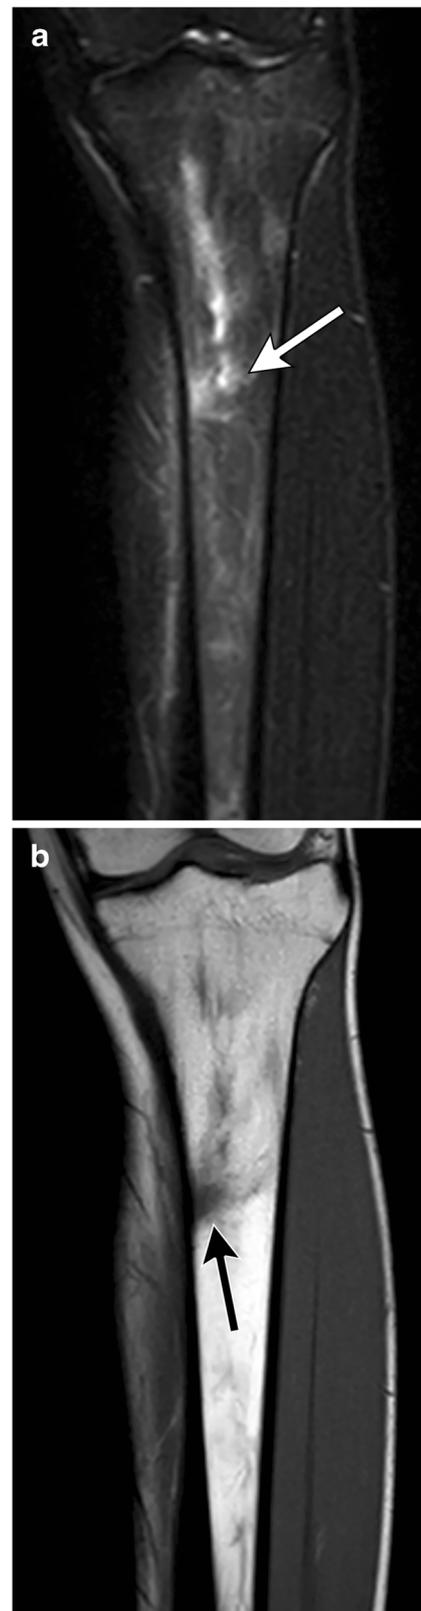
A 16-year-old girl runner with tibial stress fracture. a Coronal STIR MRI image through the tibia demonstrates bone marrow edema in the mid tibial diaphysis (*arrow*). b Coronal T1-weighted image from the same study demonstrates corresponding linear low signal (*arrow*) consistent with a stress fracture
